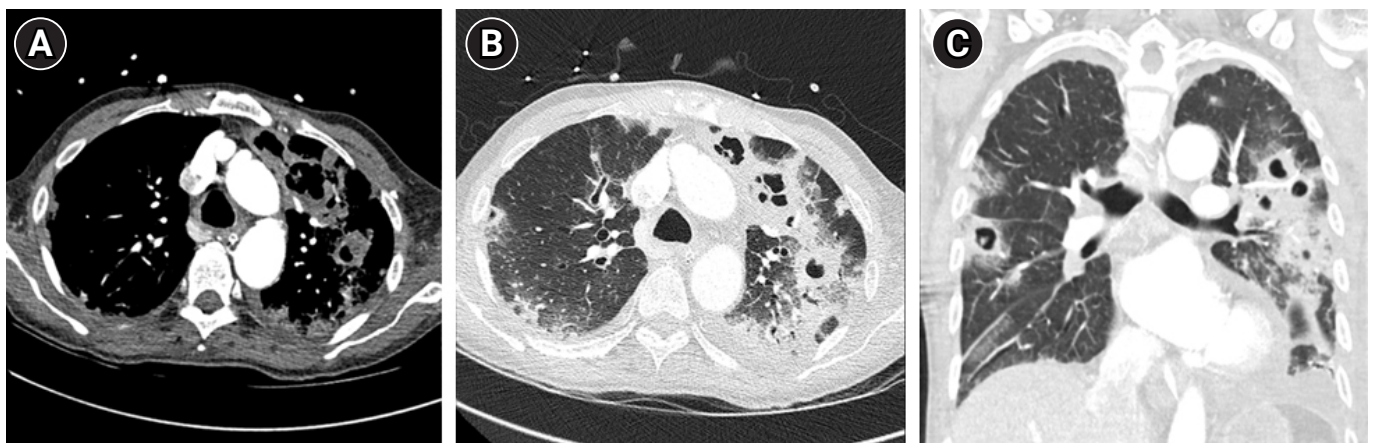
(A) Chest computed tomography (CT) showing multiple low attenuated consolidations and cavities in both lungs in the axial view of CT (mediastinal window). The cavities were surrounded by ground-glass opacity in both lungs called a “Halo sign” in transverse (B) and coronal (C) views of CT (lung window).
